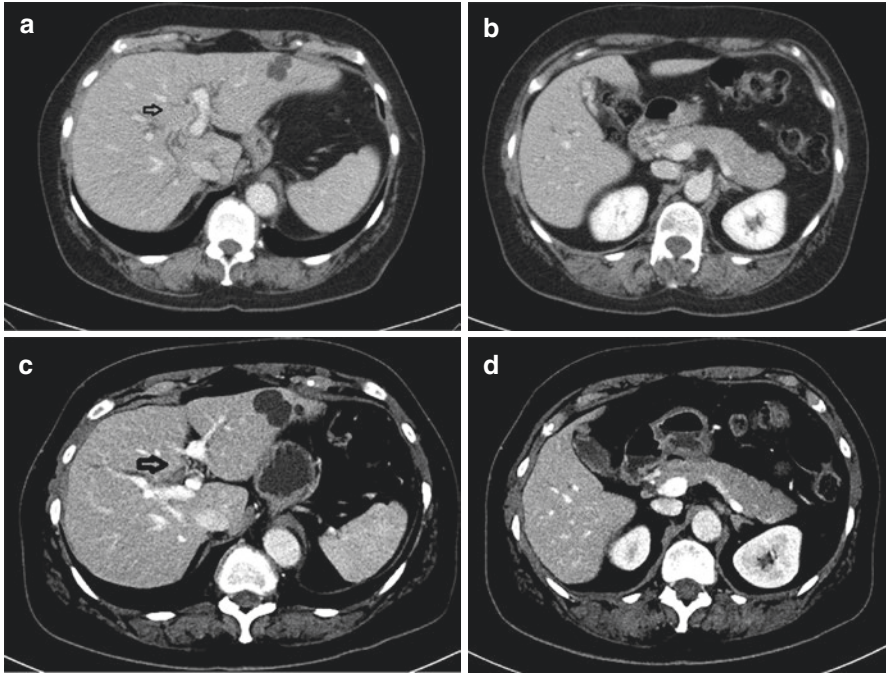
Case 2: IgG4-related sclerosing cholangitis. (a) CT at first presentation: centrally obstructing liver tumor with dilatation of the intrahepatic bile ducts. (b) CT at first presentation: pancreas showing mild swelling (“sausage”-like appearance), compatible with autoimmune pancreatitis. (c) CT after prednisone treatment: decrease in both size of liver tumor and dilatation of the intrahepatic bile ducts. (d) CT after prednisone treatment: pancreas showing less swelling
